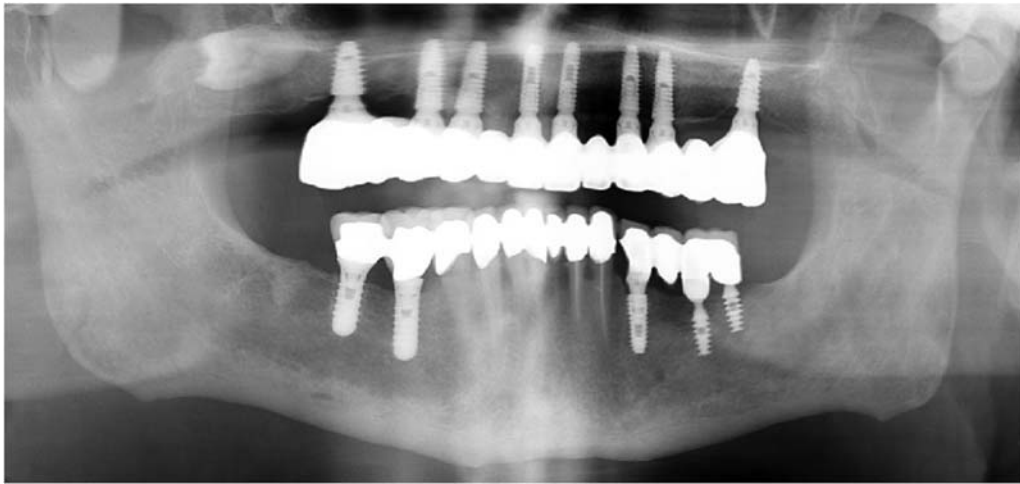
Six-month orthopantomogram (OPT).
